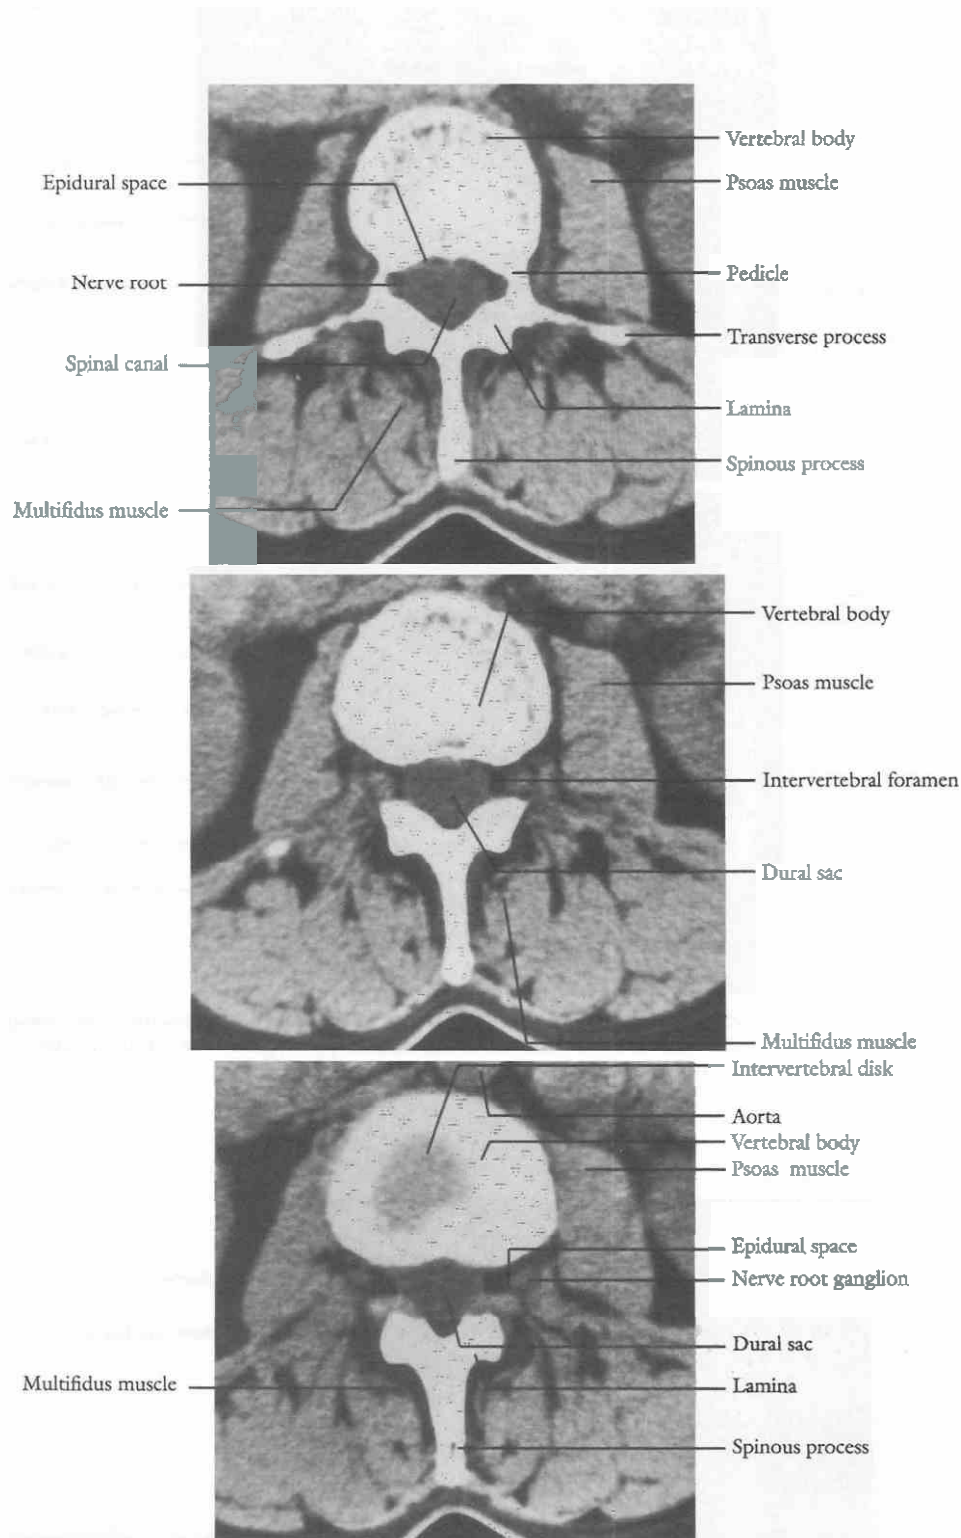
Top*, Axial CT scan through the upper half of the vertebral body demonstrating the full circle of bony canal made by the vertebral body, pedicles, laminae, and the spinous process. *Center*, Axial CT scan through the intervertebral foramen in the midlumbar region. Low attenuation of fat and the slightly increased attenuation of ligamentum flavum help to determine the border of the thecal sac. *Bottom*, Axial CT scan through the midvertebral body in the lumbar region. The ganglion is seen in the most proximal portion of the intervertebral foramen (canal) surrounded by fat.
